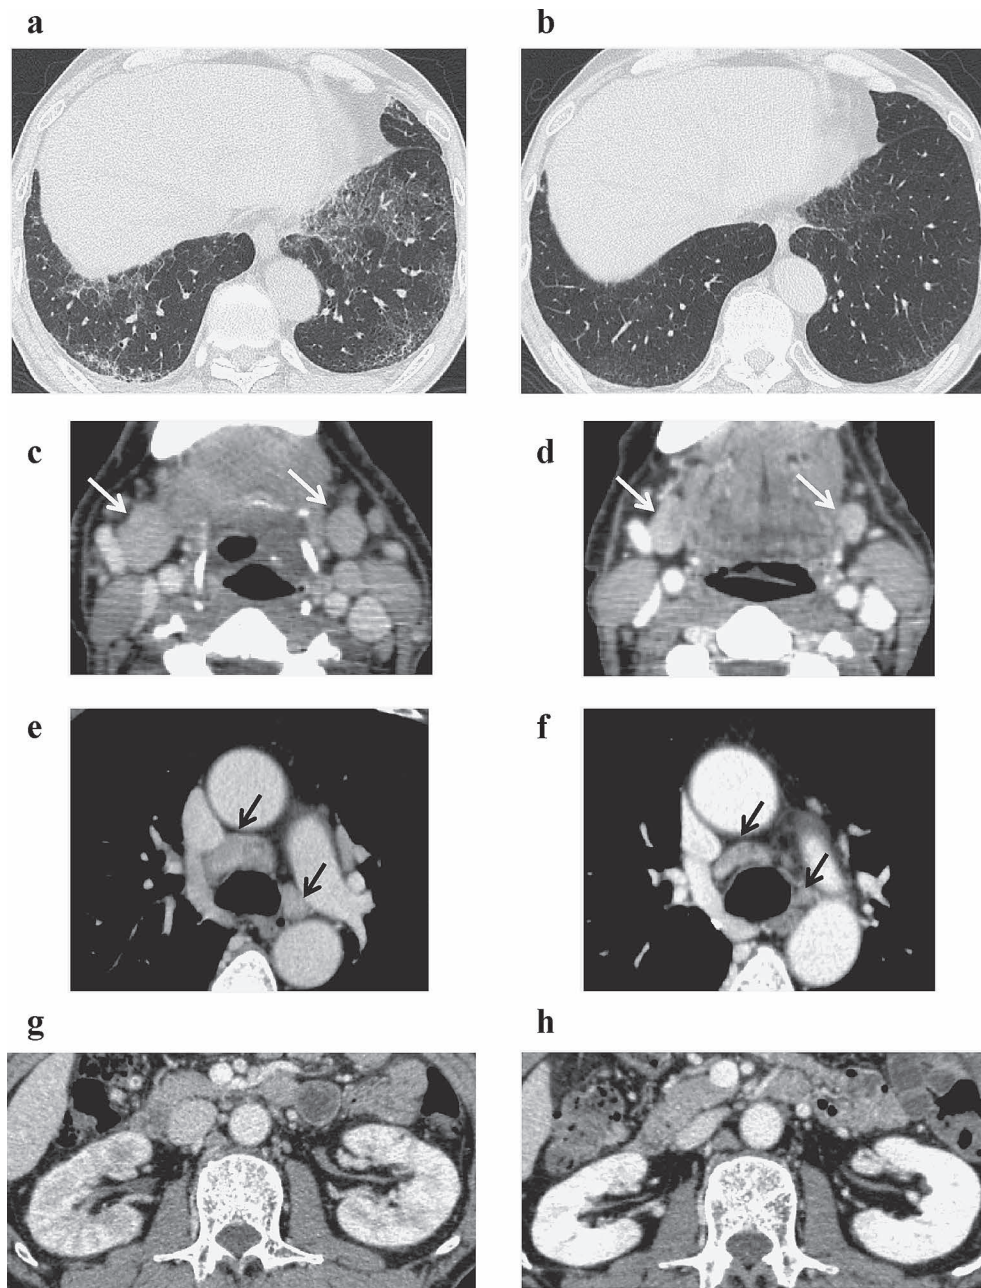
Chest high-resolution computed tomography.
